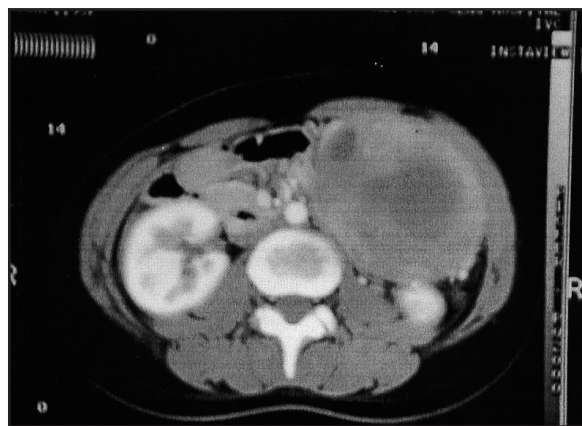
Abdominal CT scan showing a large well-circumscribed mass of soft tissue density with a heterogeneous appearance
